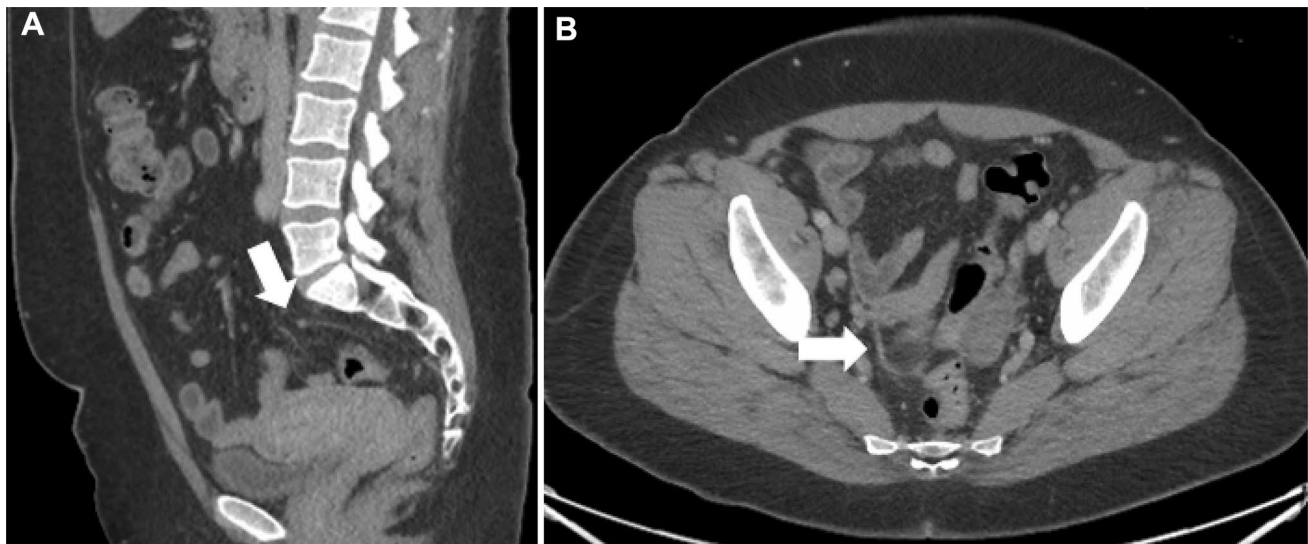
34-year-old female who presented with bilateral lower quadrant pain. Sagittal (A) and axial (B) CT demonstrates subtle peritoneal thickening in the pelvis, with mild associated inflammatory
